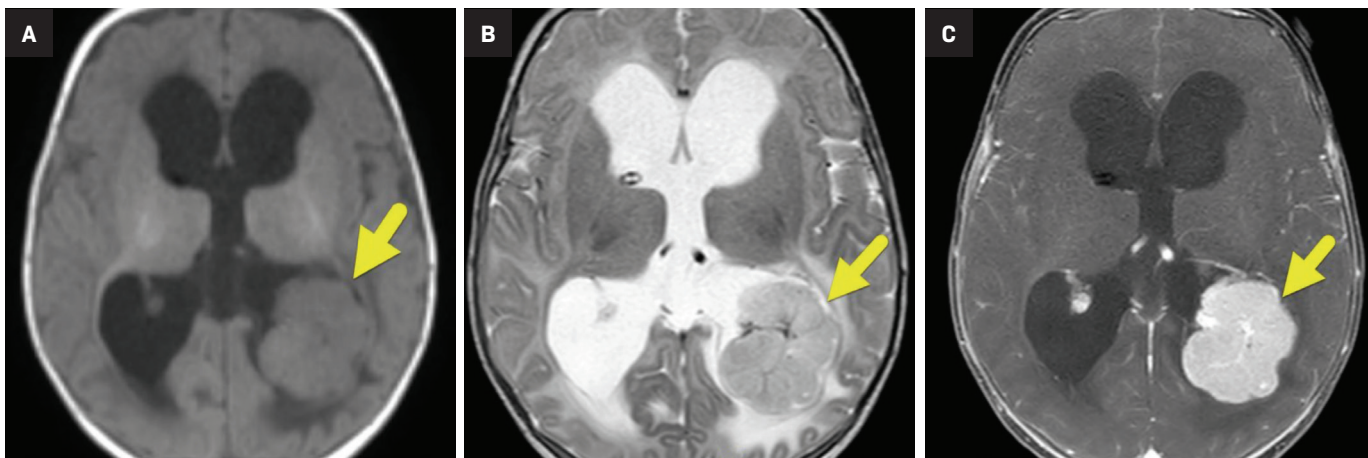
(A) Axial T1 MRI shows the lobulated, intermediate signal intensity mass (arrow) filling the atrium and occipital horn of the left lateral ventricle. (B) The mass (arrow) is relatively isointense to white matter on T2 images with the hypointense central vascular pedicle. Vasogenic edema is present in the occipital (short arrow) and posterior temporal lobes adjacent to the tumor. (C) On axial T1 postcontrast images, the tumor (arrow) enhances avidly.
